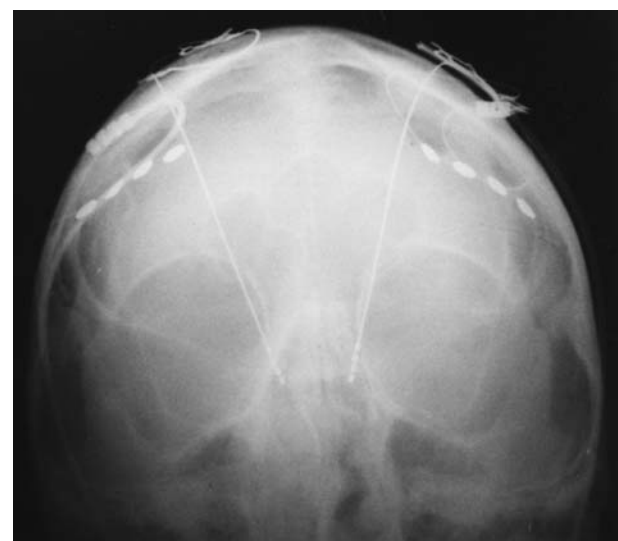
Radiograph of a Parkinsonism case with a double STN and MCS stimulator (Ref. [9])
